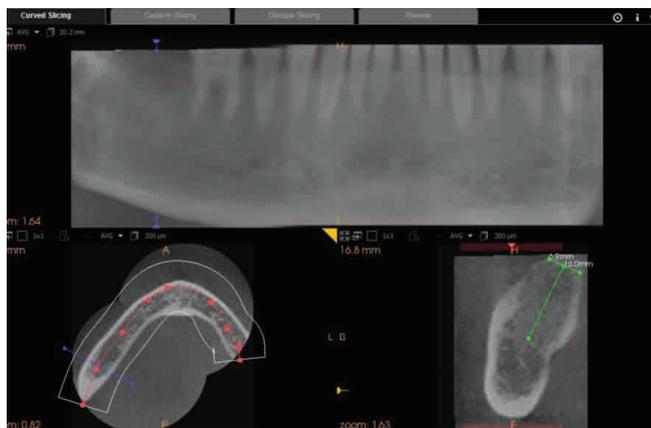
CBCT analysis to assess available alveolar ridge dimensions
